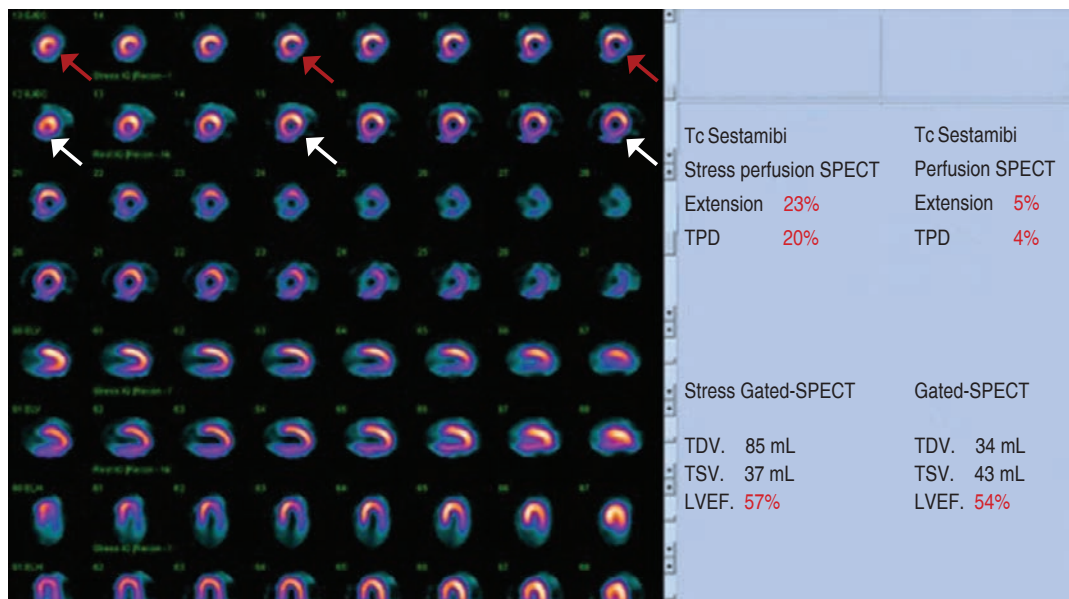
High risk Tc Sestamibi rest/stress Gated-SPECT. Rest image shows an extensive and moderate perfusion defect (white arrows) in the entire inferolateral wall, stress image shows moderate to severe reversibility (red arrows), equivalent to a non-transmural inferolateral infarction with moderate to severe ischemia.
